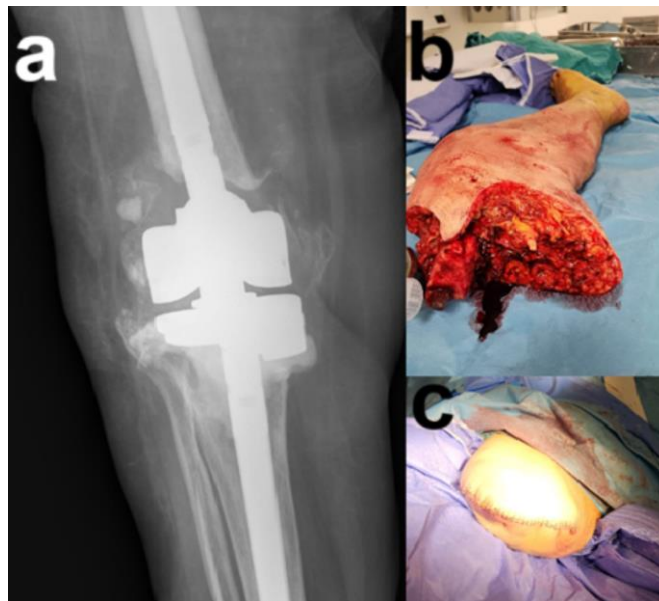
a) Preoperative radiographic image of the patient's knee. b, c) Appearance of the extremity after transfemoral amputation.
